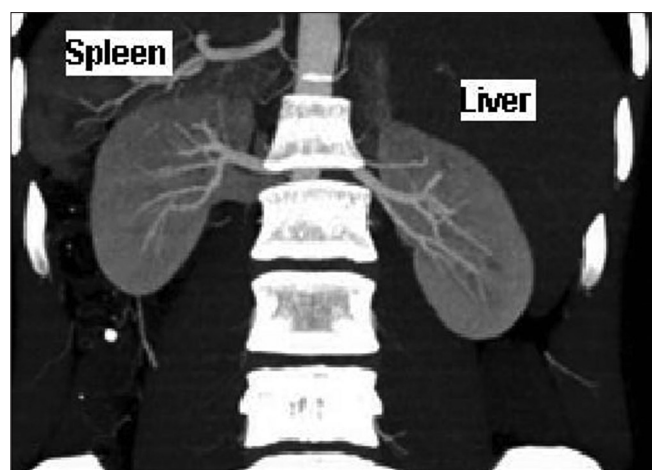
In this computed tomography image, the liver is on the left side and spleen is on the right side suggestive of complete situs inversus
